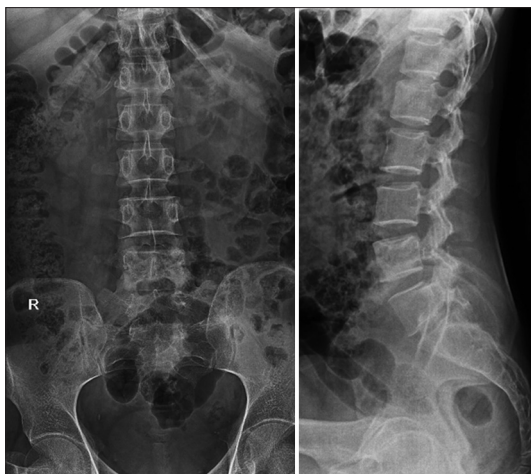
Preoperative X-ray showing sclerosis of L4 vertebral body
